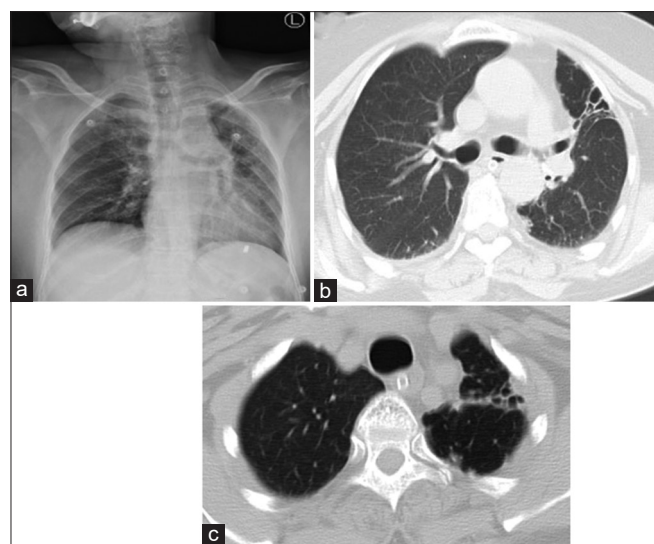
(a) Frontal chest radiograph reveals left lung fibrosis. Non-contrast CT thorax (b and c) shows left lung fibrotic changes along with tractional bronchiectasis
